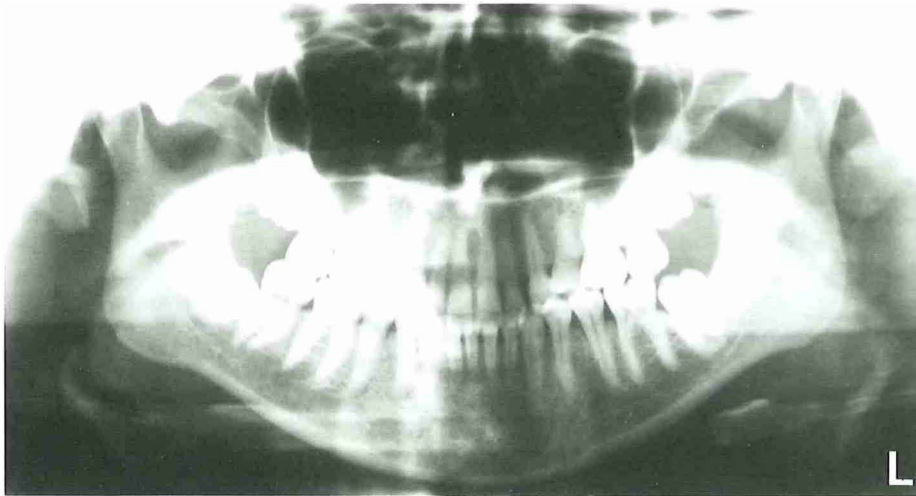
Orthopantomogram of an 18-year-old girl showing secondary retention of the mandibular left second molar. Two years before the retained molar had been luxated after removal of the third molar. No eruption was observed.
